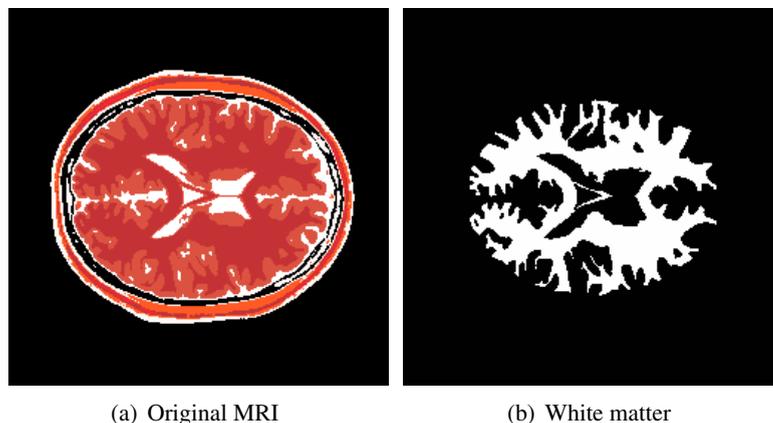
Reference white matter segmentation of original labeled MRI image.
